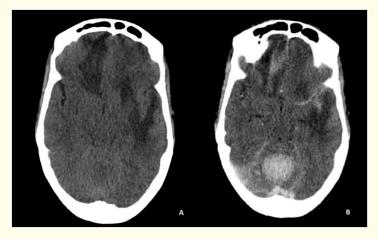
A: CT in axial section before injection of PDC showed the edema, B: After injection of PDC, showed significant enhancement of the dural-based lesions (supra and infra tentorial).
